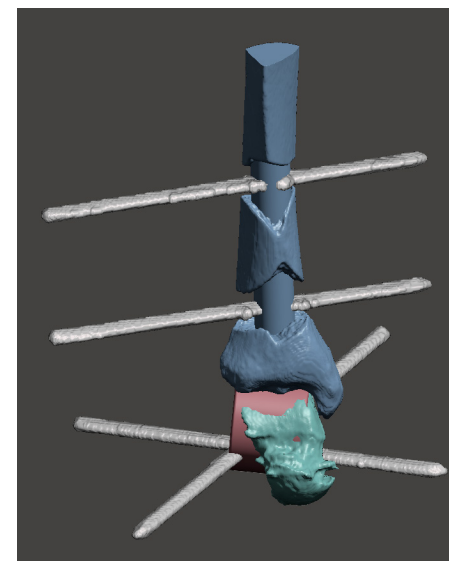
Results of the CT-scan
